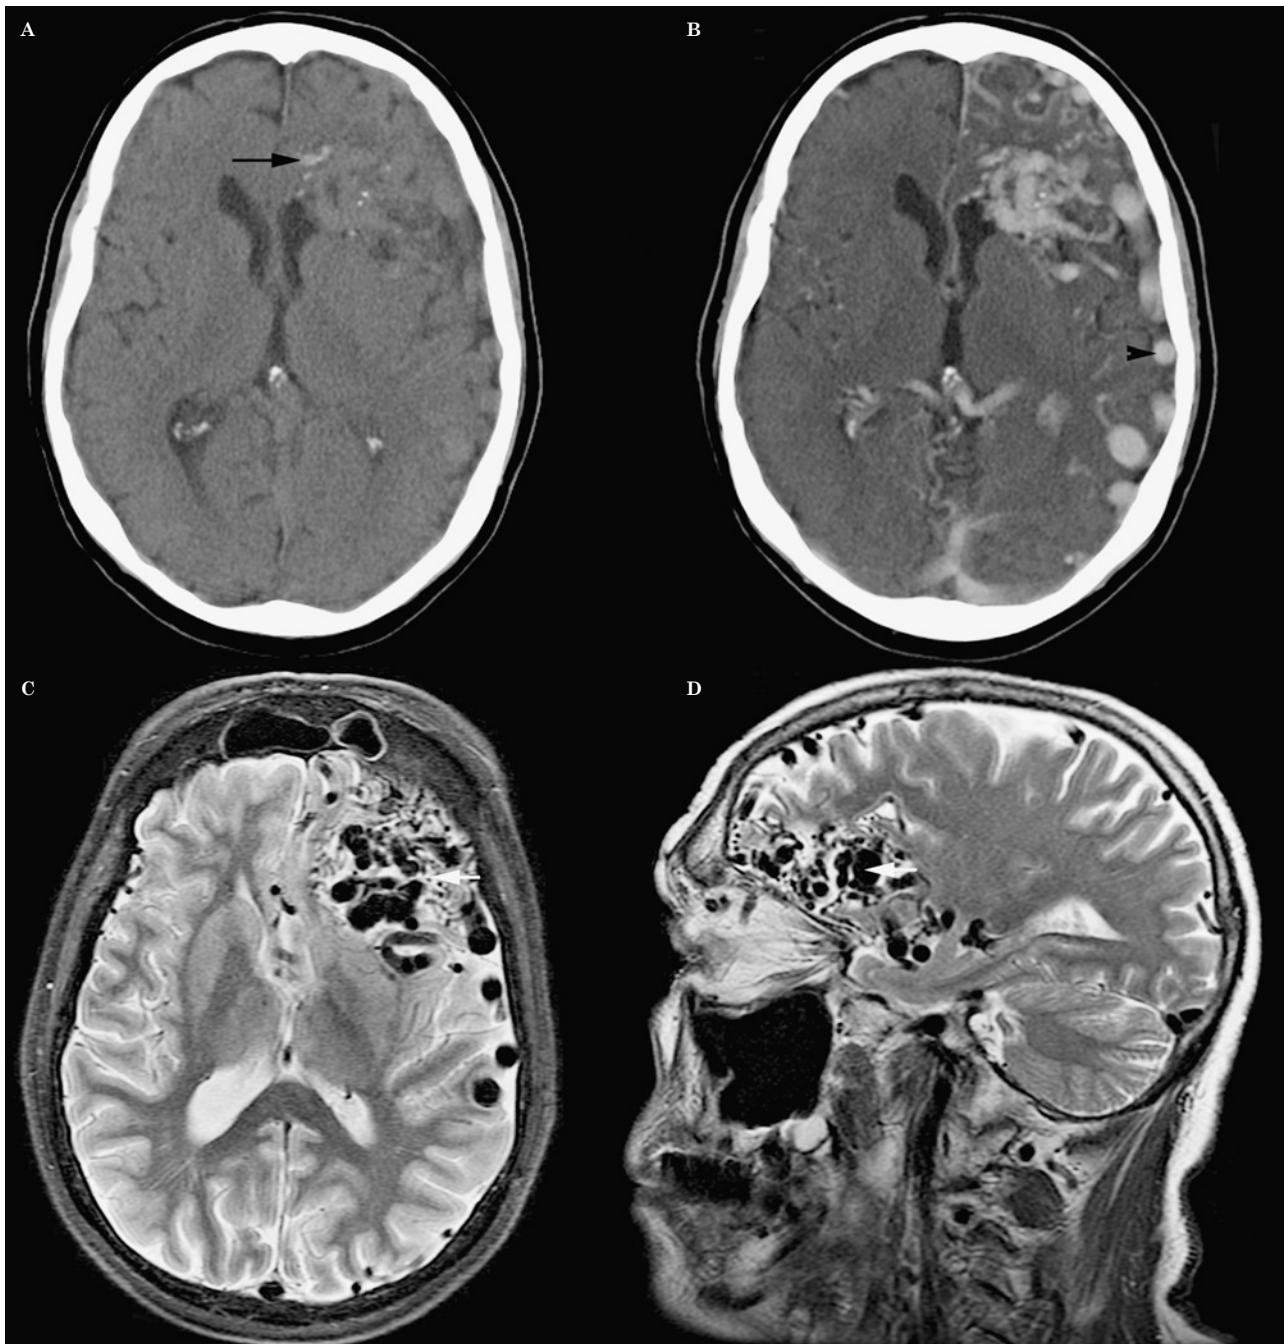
Arteriovenous malformation. A) Nonenhanced CT image demonstrates foci of coarse calcifications (arrow) in the left frontal lobe, associated with an underlying AVM. B) Post-contrast CT at the same level shows avid enhancement of the nidus, feeding and draining vessels. Note is made of prominent superficial cortical veins (arrowhead) overlying the left convexity. Axial (C) and sagittal (D) T2W images demonstrate a 'bag of worms' appearance (white arrows) of prominent flow voids associated with the AVM.
